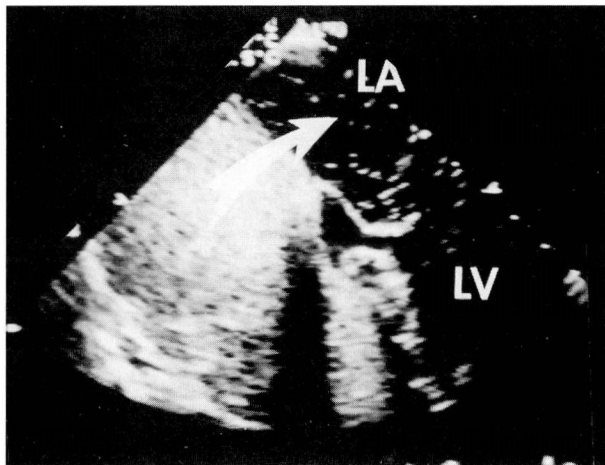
Transesophageal echocardiogram with agitated saline injected into the right atrium, showing the presence of a patent foramen ovale, with bubbles crossing into the left atrium (LA). Note the bubbles in the left atrium (arrow). (LV, left ventricle)
